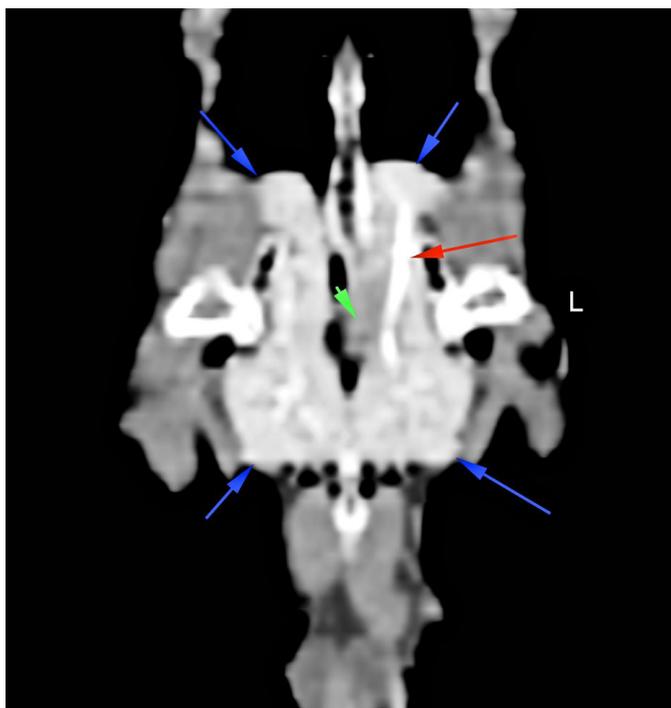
CT Coronal plane Case 1. Blue arrows - right and left kidneys. Red arrow - left ureter. Green arrow - the tumour shadow, creating a slight impression on the left kidney. Compare to Figure 3.
